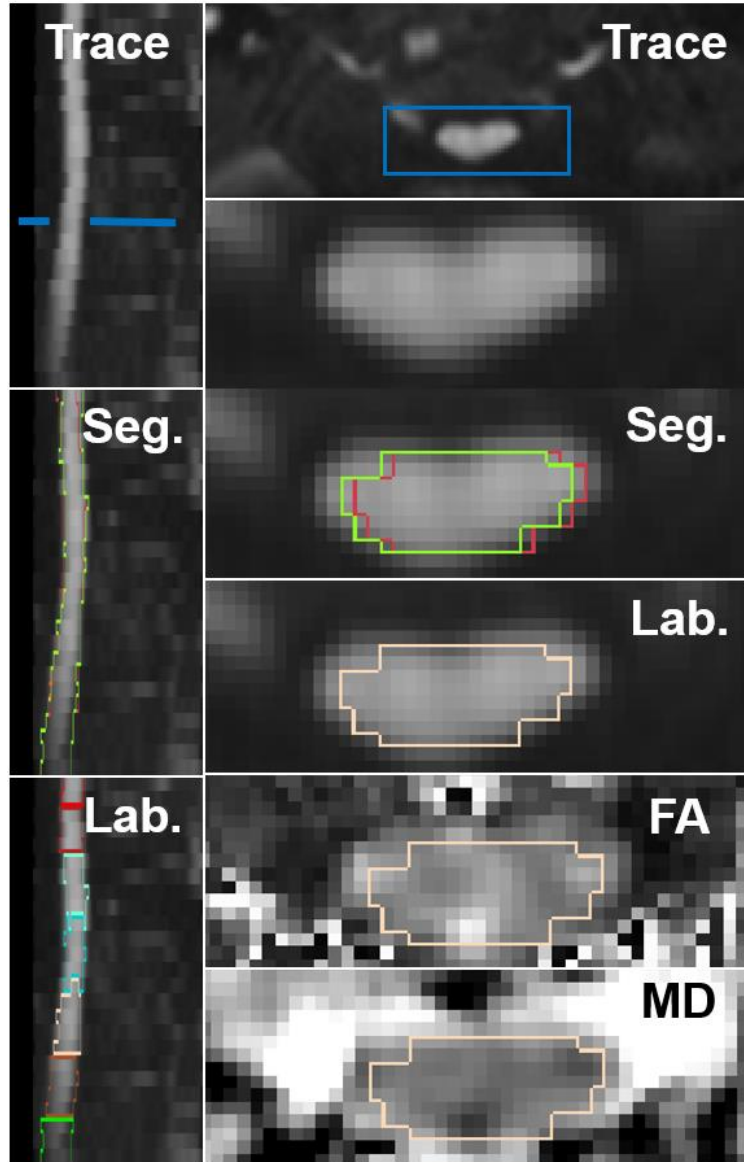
Spinal cord diffusion MRI scan and analysis at site of compression. Left side shows sagittal sections of the trace images of the spinal cord, right side shows axial views at reference (blue markers on top sagittal section). Zoomed in section on the segmentations (seg.) shows improved alignment (green) to spinal cord after slice-wise registration compared to 6 DOF registration (red). Vertebral labeling (Lab.) separates different vertebral levels for analysis and used to calculate mean measures from the FA and MD maps at each level.
